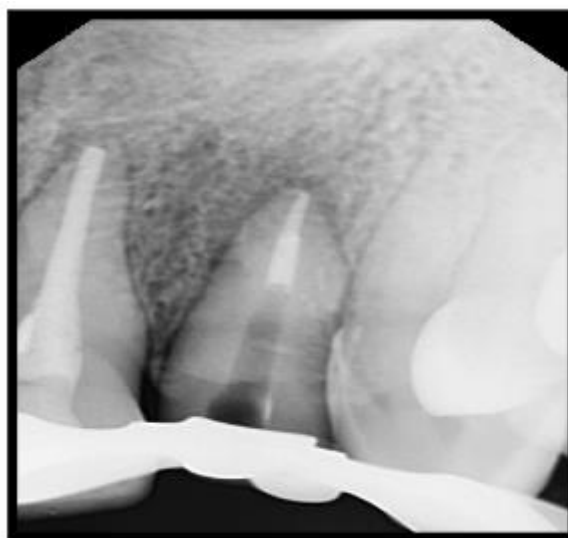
Radiograph showing extrusion and post space preparation
